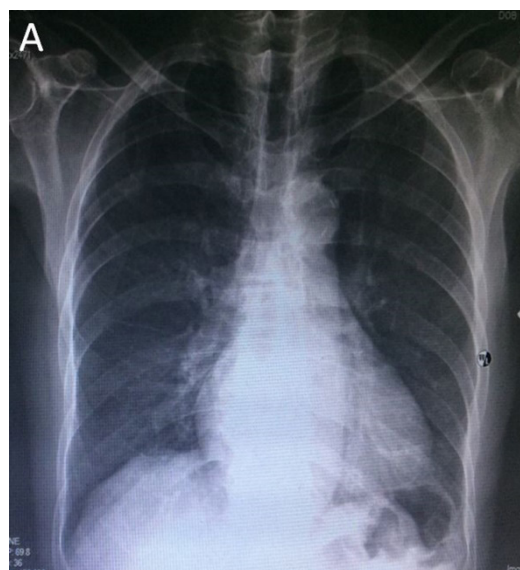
Chest radiograph showing as normal finding from PA view
